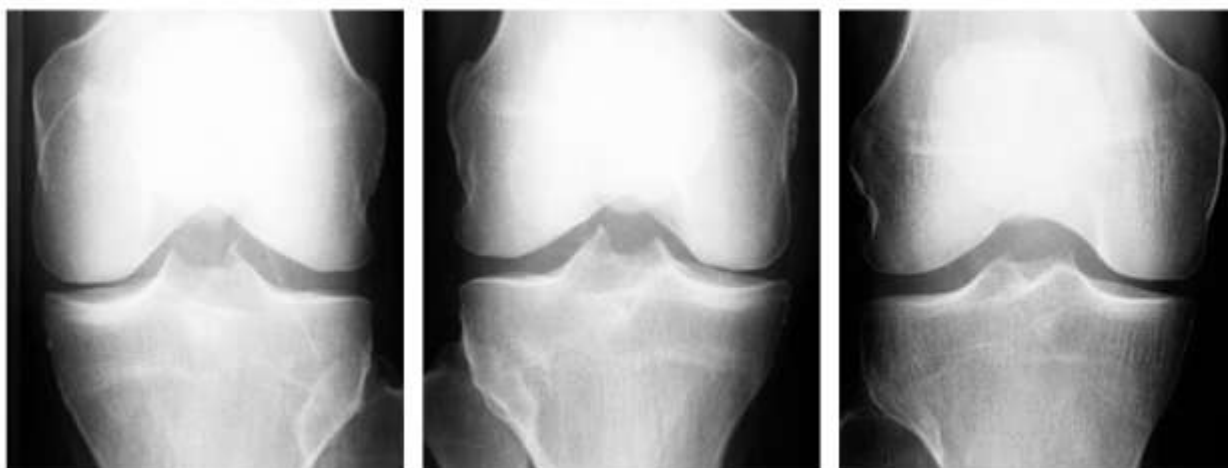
Representative Knee Radiographs Demonstrating Typical Features of Knee Osteoarthritis
